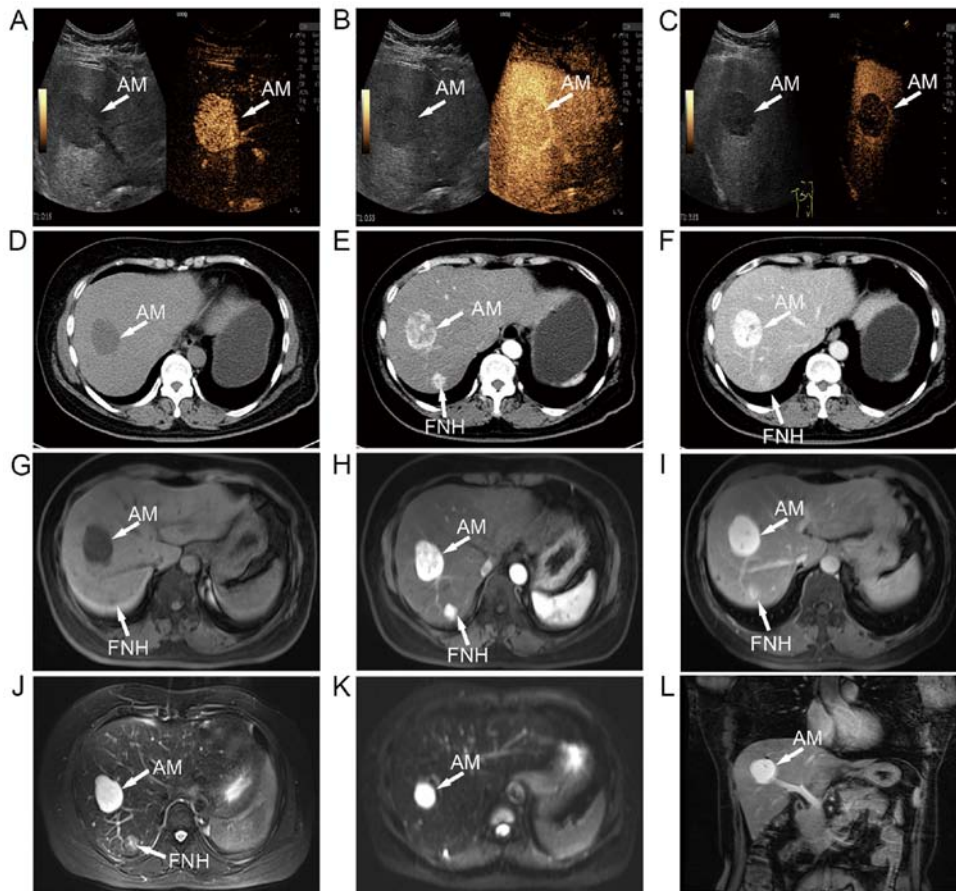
Hepatic imaging examination. Contrast-enhanced ultrasound of the lesions in the (A) arterial, (B) venous and (C) delayed phases. Image of CT plain scan (D) Contrast-enhanced CT of the lesions in the (E) arterial and (F) venous phases. (G) Image of T_1 -weighted MRI. T_1 -weighted MRI of the lesions in the (H) arterial and (I) delayed scan phases. (J) Image of T_2 -weighted MRI. (K) Diffusion-weighted imaging was applied to assess the lesion. (L) Image showing the AM nodule in the coronal view. AM, angiomyxoma; FNH, focal nodular hyperplasia; CT, computed tomography; MRI, magnetic resonance imaging.
